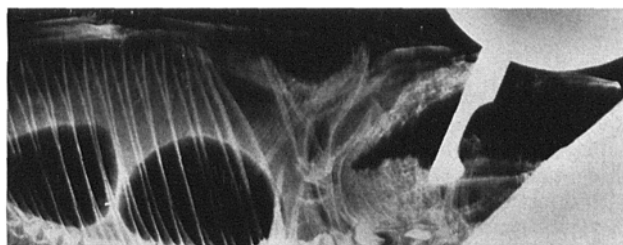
A radiographic lateral projection of the fish in position. The guide is correctly centred on the parasphenoid prominence. Note that the guide prevents closure of the fish's mouth.
